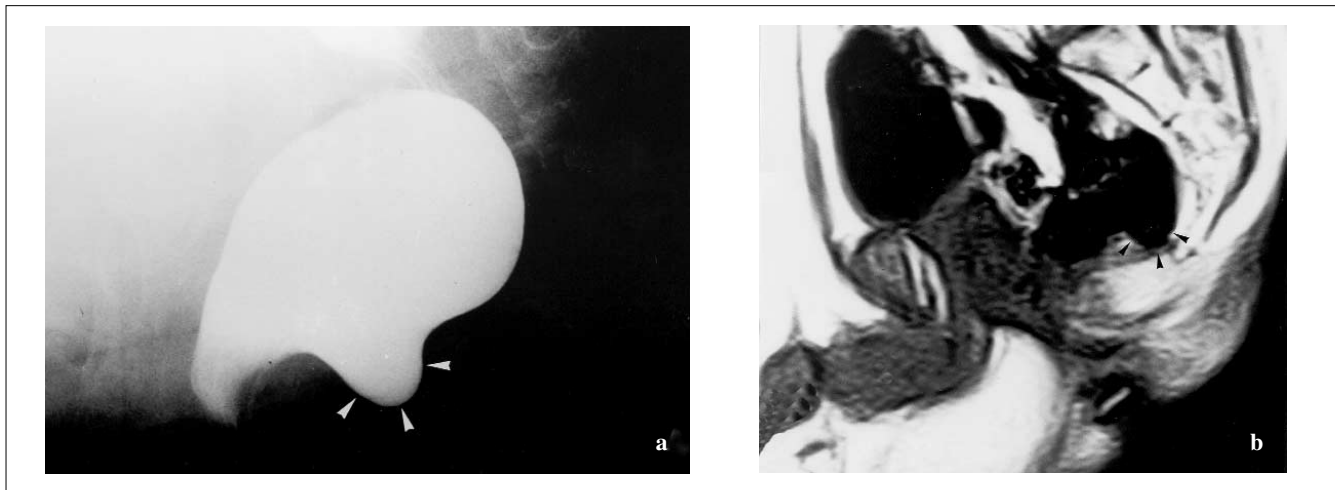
a A posterior rectocele (*arrowhead*) between the puborectalis and coccyx in the pushing phase. b MRI also revealed this posterior rectocele (*arrowhead*) between the puborectalis and coccyx
